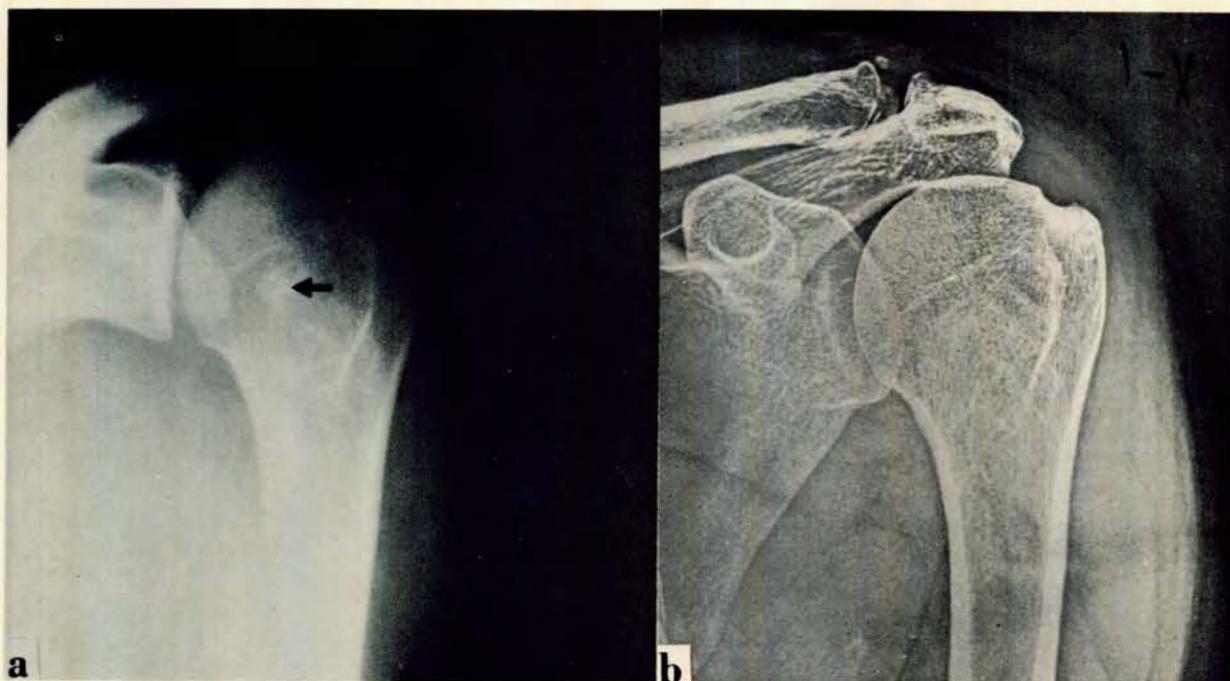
Bone survey of a Gulf of Mexico diver, which proved positive for osteonecrosis. (a) Conventional roentgenogram of L shoulder (osteonecrotic area marked with arrow) required less exposure of subject and demonstrates lesions as well, if not better, than (b) the xeroradiogram.
